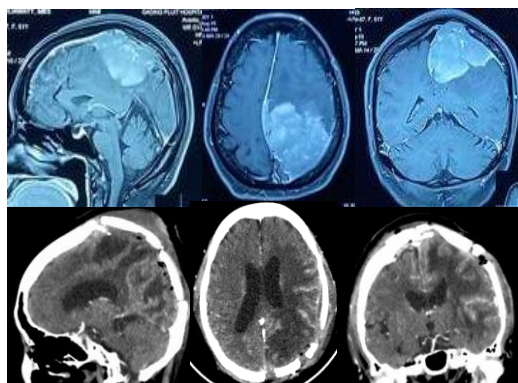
Comparison of pre-operative (contrast MRI) and post-operative (non-contrast CT) imaging in sagittal, axial, and coronal views for case 2
